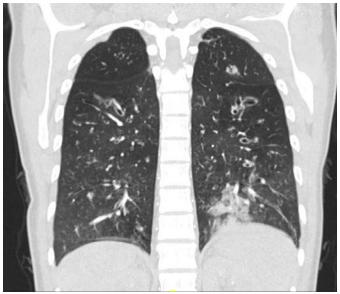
Axial slice of CT angiogram of the chest demonstrating bronchiectasis and right lower lobe infiltrate.
